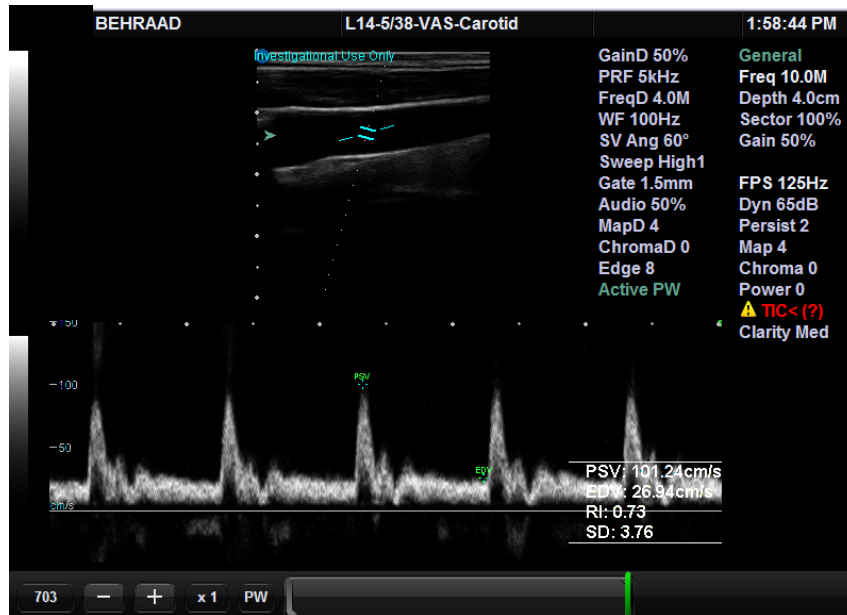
Ultrasound image of the left carotid artery with no vibration applied to the subject.
